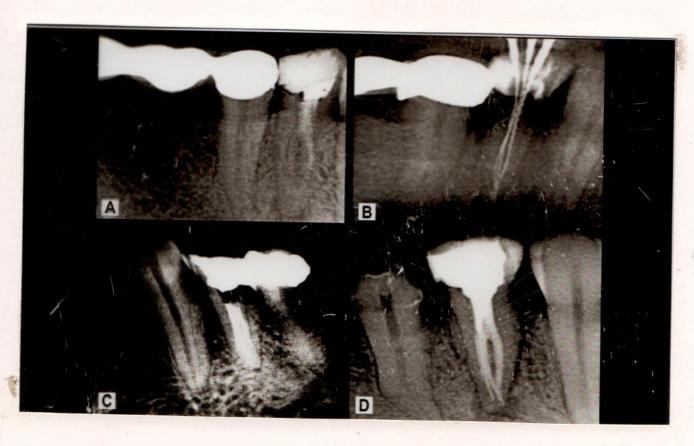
Radiograph of mandibular first premolar
